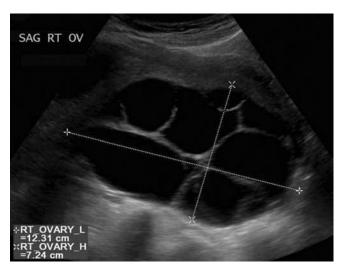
Sonogram of an ovary with multiple theca-lutein cysts in a woman with a complete hydatidiform mole.
